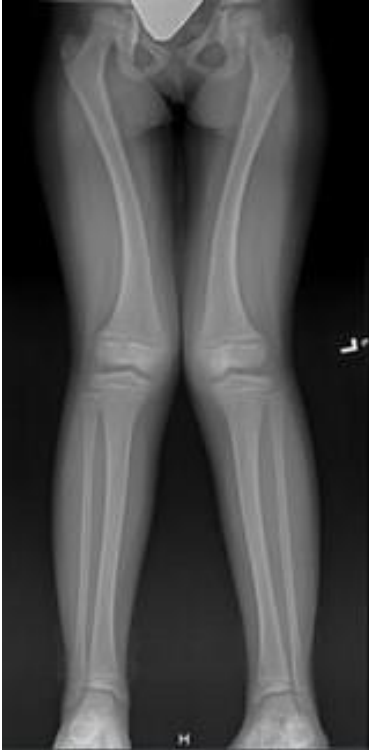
Radiograph of the lower limbs showing bilateral genu valgum in patient #1
